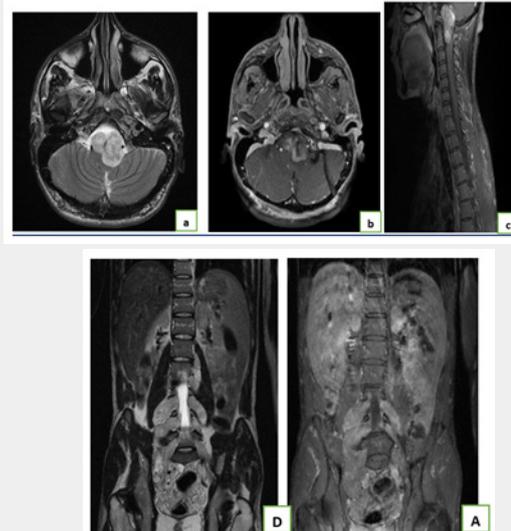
Brain MRI cut axial T2 (a) and injected (b), injected sagittal cut (c): neurofibroma in hypo signal T1, hypersignal T2, enhancing in a heterogeneous manner after injection of contrast product, extended through the C1-C2 conjugation foramen compressing the bulb and the cervical bone marrow. T2 (d) and injected corneal medullary MRI (e): Multiple extended Storied neurofibromas from D12 to the bilateral sacred e.
